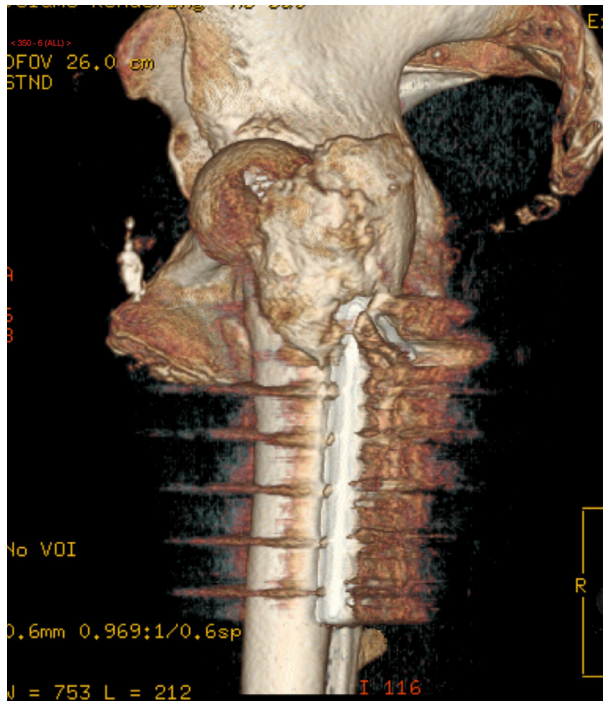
Lateral view of the CT reconstruction.
